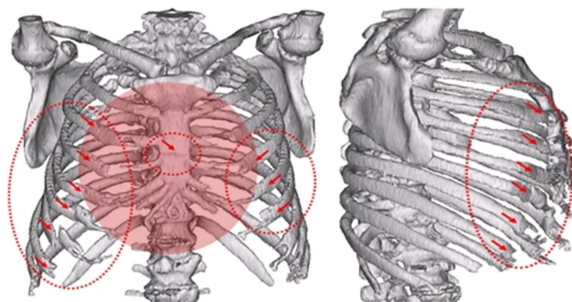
3D model of thoracic CT images (injured by airbag and seat belt)
